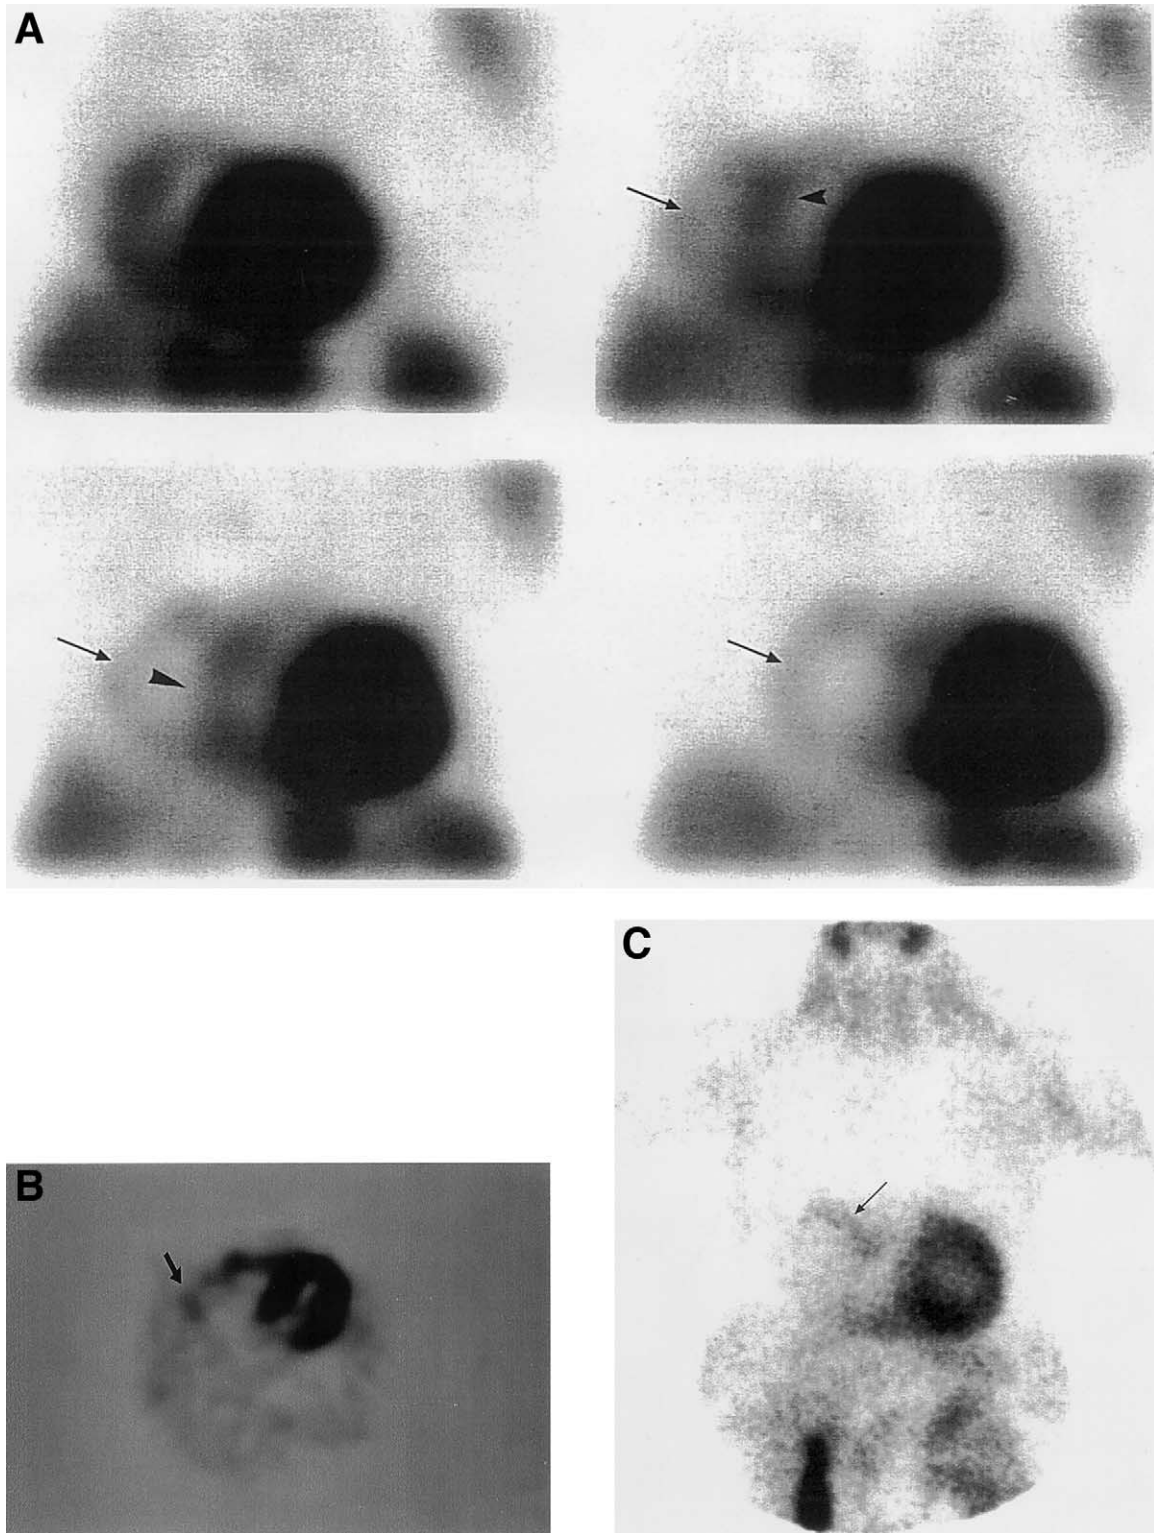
Scintigraphic images show ^{99m}Tc -methoxyisobutyl isonitrile (MIBI) uptake on the configuration of the pulmonary artery adjacent to the right ventricular activity. Short axis section (A) (arrowhead: right ventricular uptake; arrow: pulmonary artery) and horizontal long axis sections (B) of the scintigraphic study at 20th min. (arrow: pulmonary artery). Planar scintigraphic study at fourth hour (C) (arrow: pulmonary artery).
